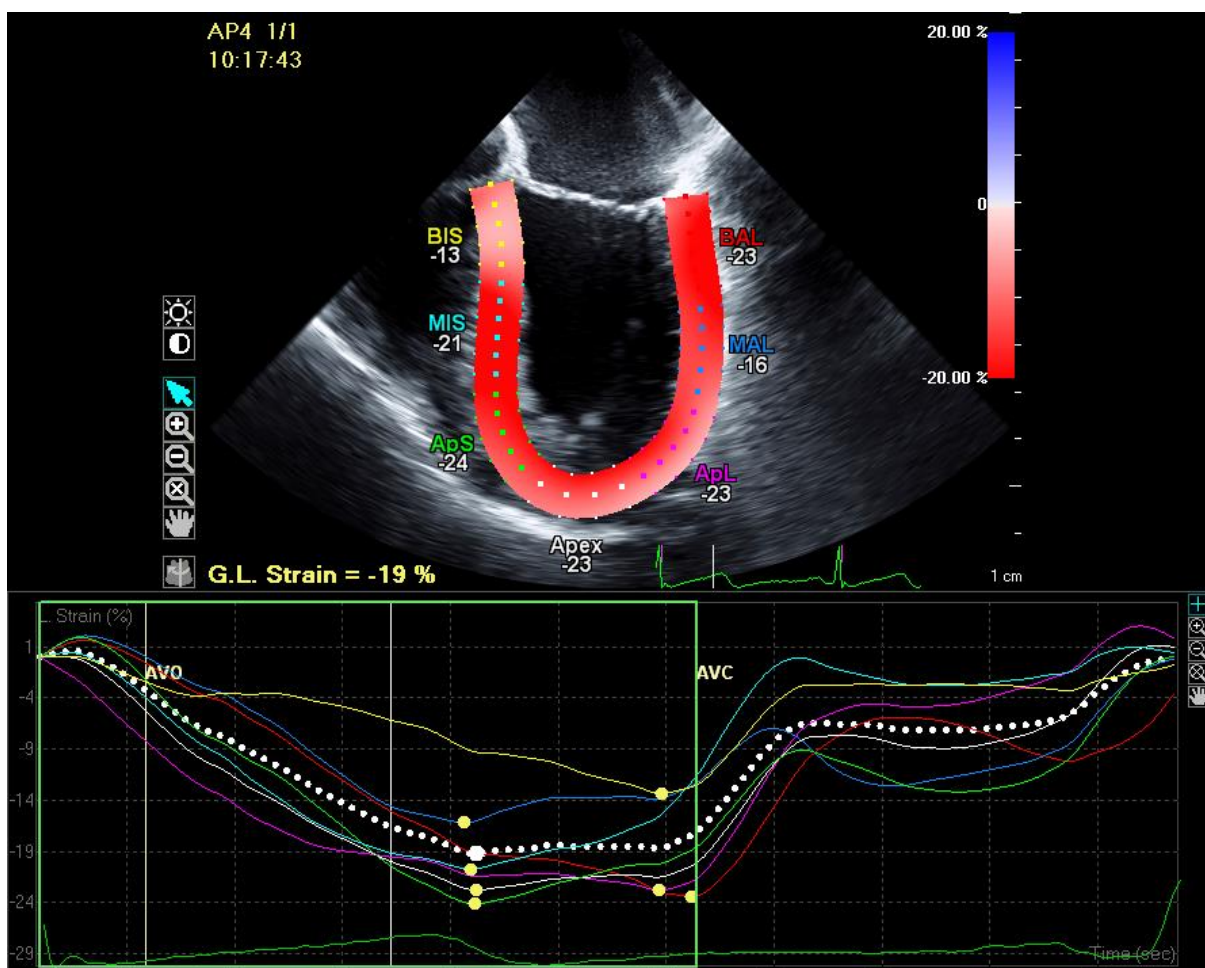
Mid-esophageal four - chamber echocardiographic view of patient no 9 depicting the left ventricle (LV), where the myocardial walls are divided into six segments distinguished by color-coded labels. Segmental strain measurements are shown adjacent to each segment. BAL – basal anterolateral, MAL – mid anterolateral, ApL – Apical lateral, BIS – basal inferoseptal, MIS – mid inferoseptal, ApS – Apical septal.
